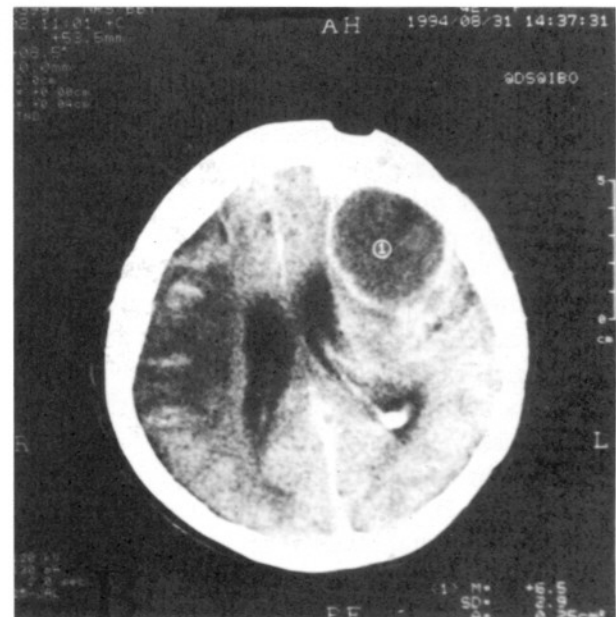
A, B: Post operative follow-up computed tomograms.
